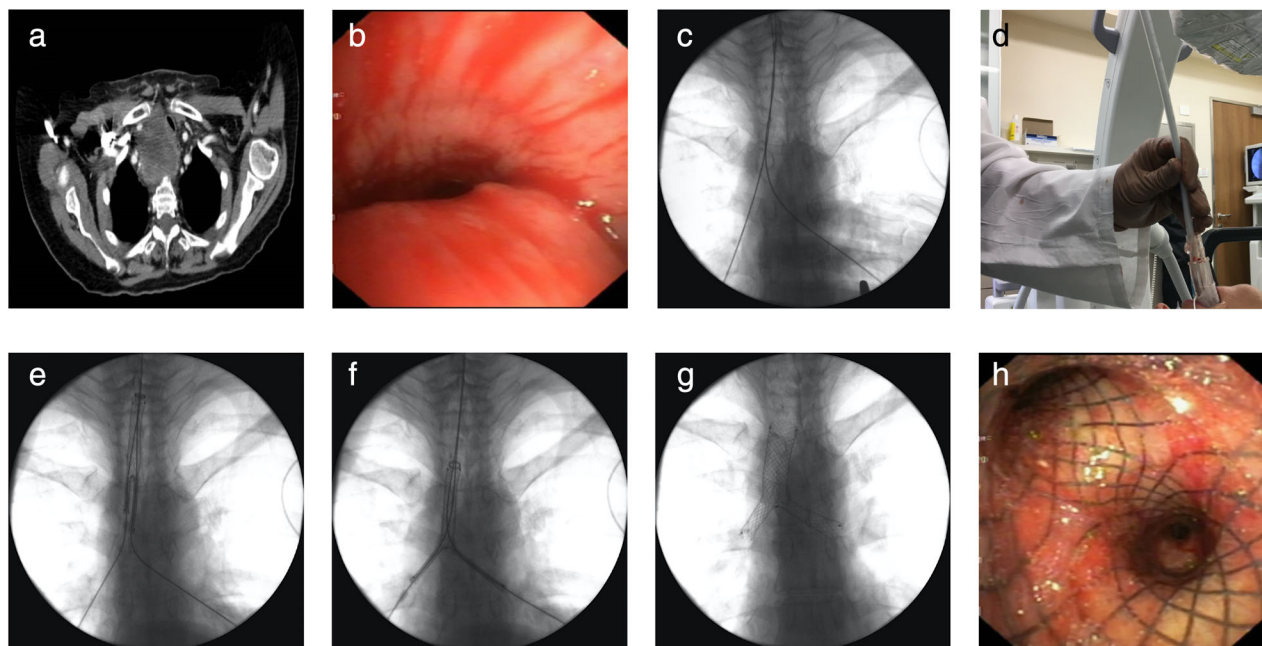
(a) Computed tomography image: Anterior mediastinal mass causing severe tracheal obstruction. (b) Bronchoscopic view: severe tracheal compression. (c) Metal wires are located in the left and right main bronchi. The location is verified with fluoroscopy. (d) Insertion of the loading system of the Y stent through the LMA. (e) Fluoroscopy image: The Y stent is advanced on the wires to the correct position. (f) Deployment of the stent in the trachea and main bronchi on the metal wires. (g) Y stent fully deployed in the correct position after removal of delivery system and wires. (h) Bronchoscopic view after Y stent deployment.
